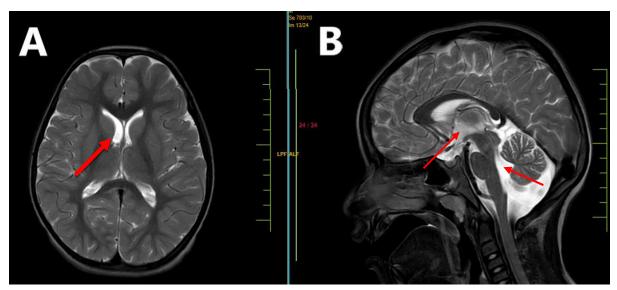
MRI T2WI axial (A) and sagittal (B) images at the level of gangliocapsular region show no obvious abnormality with the normal ventricular system
